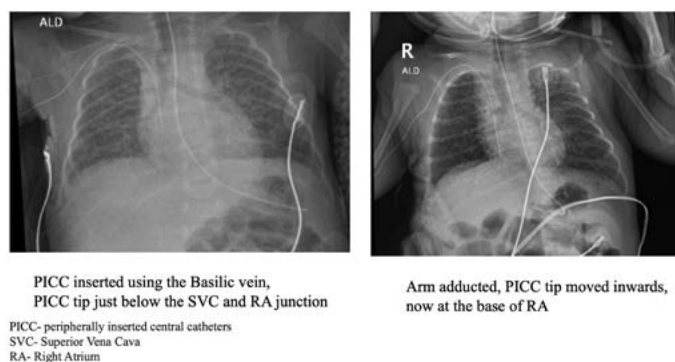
X-rays showing the movement in Peripherally Inserted Central Catheters (PICC tip) with the adduction of the arm.
